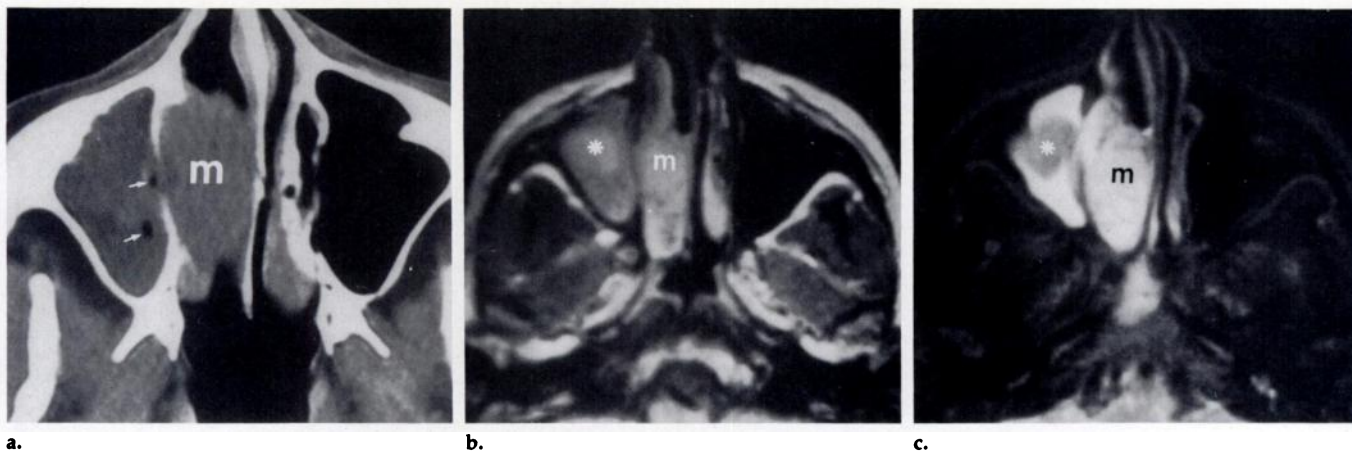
Subacute hemorrhage, mucoperiosteal reaction, and neoplasm in the nasal cavity and maxillary sinus. (a) Enhanced axial CT scan reveals nonenhancing soft-tissue mass (*m*) in the nasal cavity with a similarly attenuated mass occupying the adjacent maxillary sinus. Air density within the maxillary sinus (arrows) may be related to a recent biopsy. R = right; L = left. (b) Axial T1-weighted MR image through the maxillary sinus shows a mass with heterogeneous intensity in the maxillary sinus with a nearly round, larger anterior component (*) of higher intensity than its surroundings but similar in signal intensity to the mass in the nasal cavity (*m*). (c) Axial T2-weighted MR image shows that the larger anterior maxillary component (*) has a low signal intensity compared with the remaining mass in the maxillary sinus. This low signal intensity area proved to be subacute hemorrhage in an infected maxillary sinus. Nasal soft-tissue mass (*m*) is intermediately hyperintense; this proved to be a squamous cell carcinoma.
